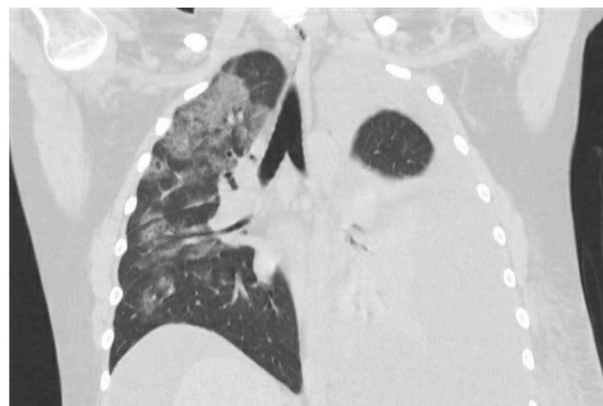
CT thorax showing right sided *Cryptococcus* pneumonia with mediastinal and hilar lymphadenopathy. There is a massive left sided pleural effusion that was present despite a therapeutic thoracentesis performed the previous day removing 1.5 L of transudative fluid.
